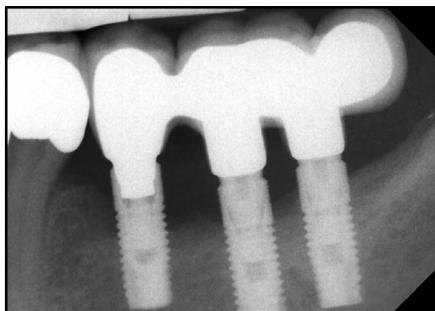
Baseline radiographs showing horizontal bone loss with a supracrestal defect height of 3 to 5 mm. In addition, vertical defects could be detected around the implants 35 and 36 with a depth of 3 mm. The combination of the clinical and radiographic diagnostics stated a clear indication for surgical, non-augmentative treatment of the periimplantitis.
